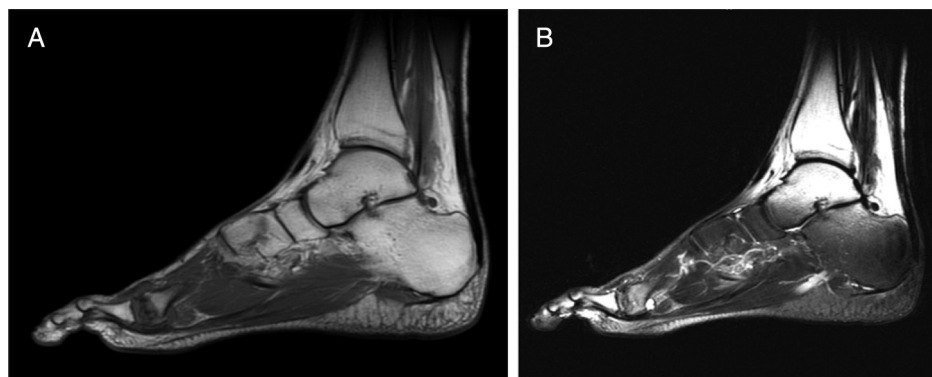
(A and B) Magnetic resonance imaging scans showing a low-signal zone within the second metatarsal head in the sagittal plane of the T₁-weighted image and a high-signal zone within the subchondral bone in the sagittal plane of the T₂-weighted image.
